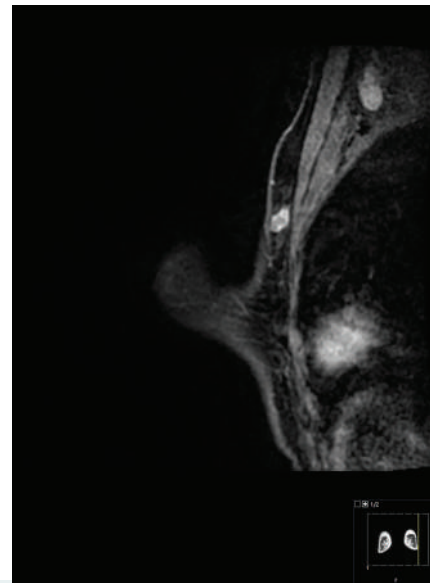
A solid mass is indicated on the breast MRI scans.
